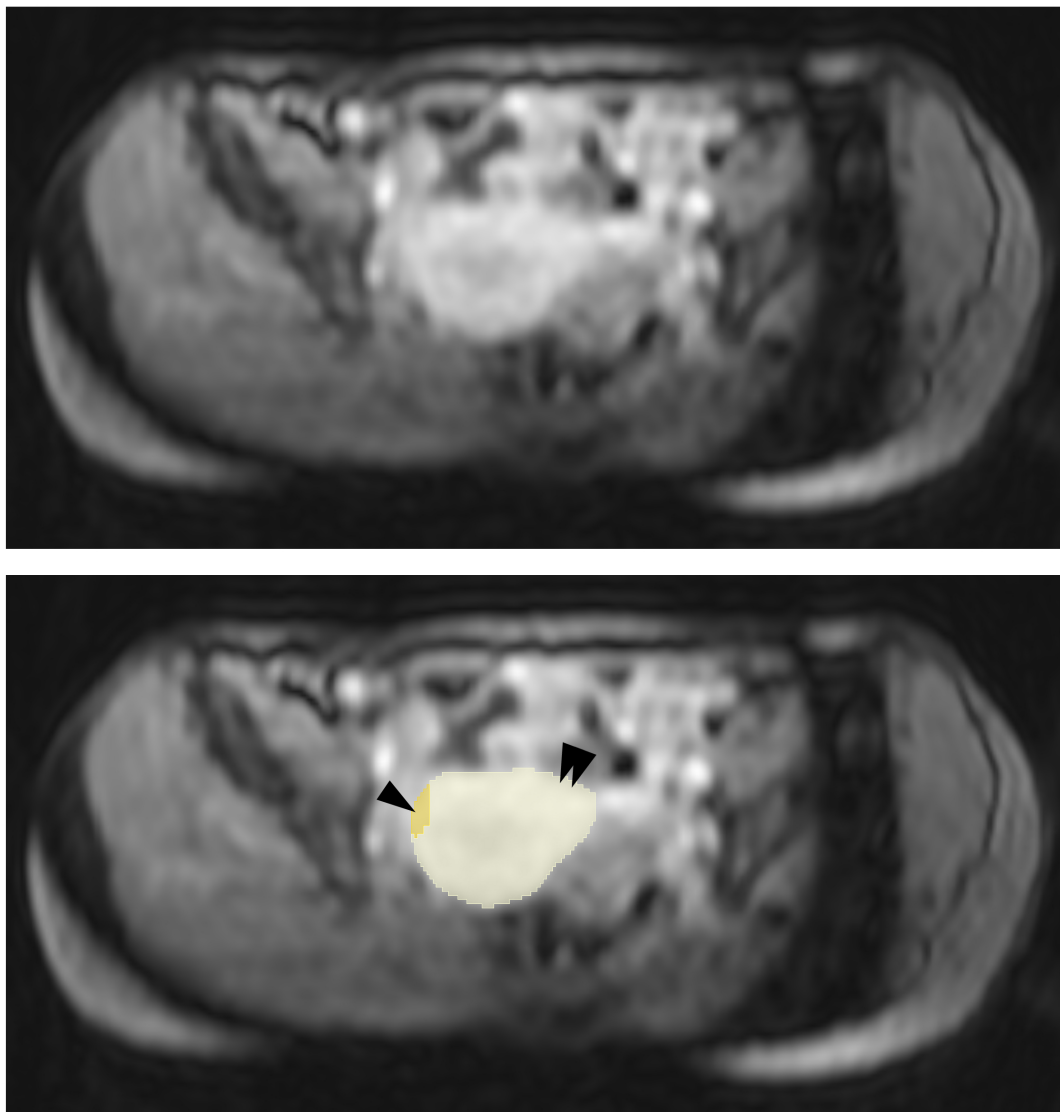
The AMOS22 dataset contains only two MRI examinations with bladder annotations. Of these two annotations, one incorrectly combines the bladder (yellow) with the uterus (beige). Consequently, we exclude the label "bladder" from our evaluation of the AMOS22 dataset.
